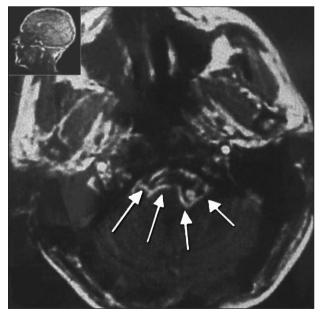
Cranial MRI (TI-weighted axial magnetic resonance scan) showed intense inflammatory reaction at the cysts located in the posterior fossa (basal cisterns, around the brainstem).
